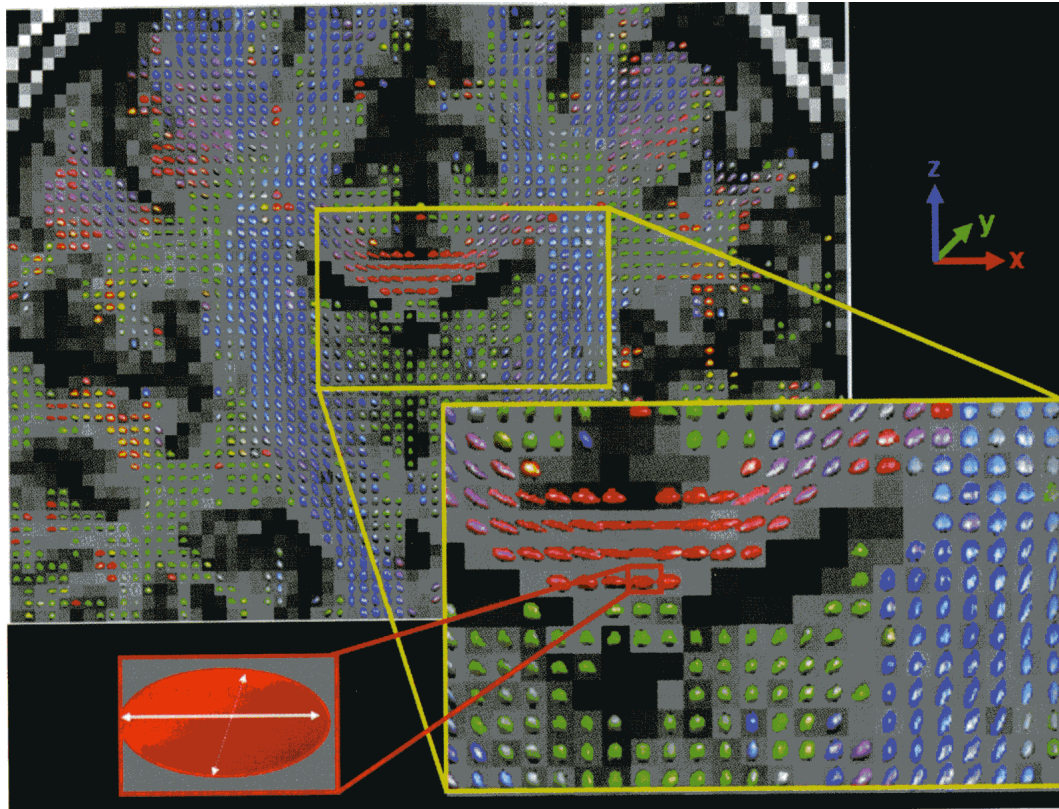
Diffusion Tensor Imaging is a sort of MRI study providing information to localize nerve fibers. (image source: [105])
